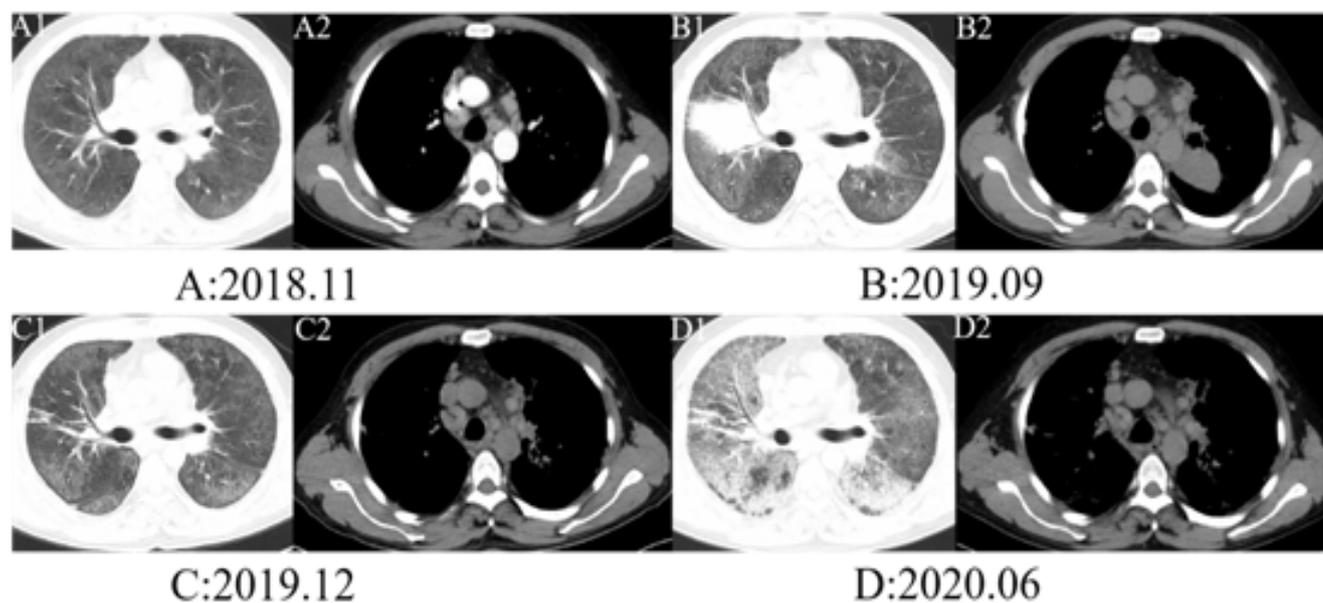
A 36-year-old man had repetitive admissions to our hospital, beginning two years ago (about 11/2018), due to severe dyspnea. His medical history revealed no remarkable events. The chest computed tomography (CT) (A1: pulmonary window, A2: mediastinal window) at that time showed diffuse ground-glass opacities in both lungs and multiple lymph nodes in the mediastinum with the lower paratracheal's largest diameter of 13mm, which were diagnosed as interstitial pneumonia and lymph node reactivity changes. After anti-inflammatory treatment, the above symptoms improved. After ten months (09/2019), the patient presented with dyspnea, chest pain, cough, sputum, hemoptysis, and fever for two weeks. The blood examination showed elevated white blood cells of $17.39 \times 10^9/\text{L}$. The chest CT (B1: pulmonary window, B2: mediastinal window) indicated diffuse ground-glass opacity with focal consolidation in the right upper lobe and enlarged mediastinal lymph nodes. Infectious disease was suspected. Biopsy of the right lung and of a mediastinal lymph node showed non-necrotizing granulomatous inflammation and lymph node tissue with a few carbon deposits. Three months after anti-inflammatory treatment, the above symptoms improved. Chest CT (C1: pulmonary window, C2: mediastinal window) on 12/2019 showed that the consolidation in the right upper lobe had fully disappeared with persistent fibrous tissue and diffuse ground glass opacities. However, after six months (06/2020), this patient developed dyspnea again. The chest CT (D1: pulmonary window, D2: mediastinal window) showed significant deterioration with extensive ground-glass opacities, interlobular/intralobular septal thickening, diffuse consolidations in both lungs and enlarged lower paratracheal lymph nodes.
